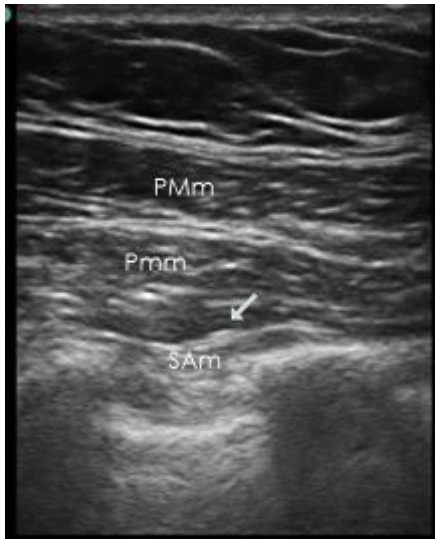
Ultrasound image post 2nd injection of PECS II Block
